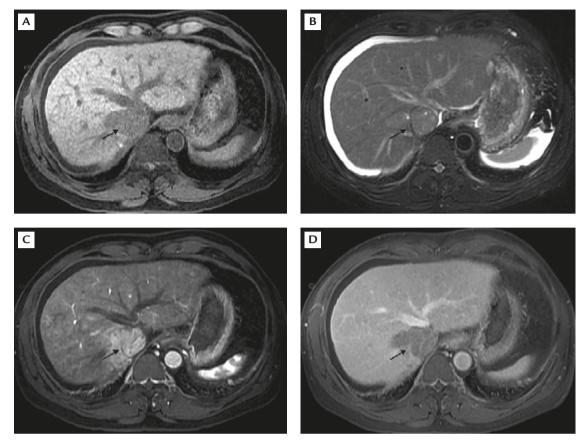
Abdominal magnetic resonance imaging demonstrates a hepatic mass in segment 7: (A) low intensity on T1-weighted imaging (arrow); (B) high intensity on T2-weighted imaging (arrow); (C) early global contrast enhancement in the arterial phase (arrow); (D) rapid contrast washout in the portal venous phase (arrow).
